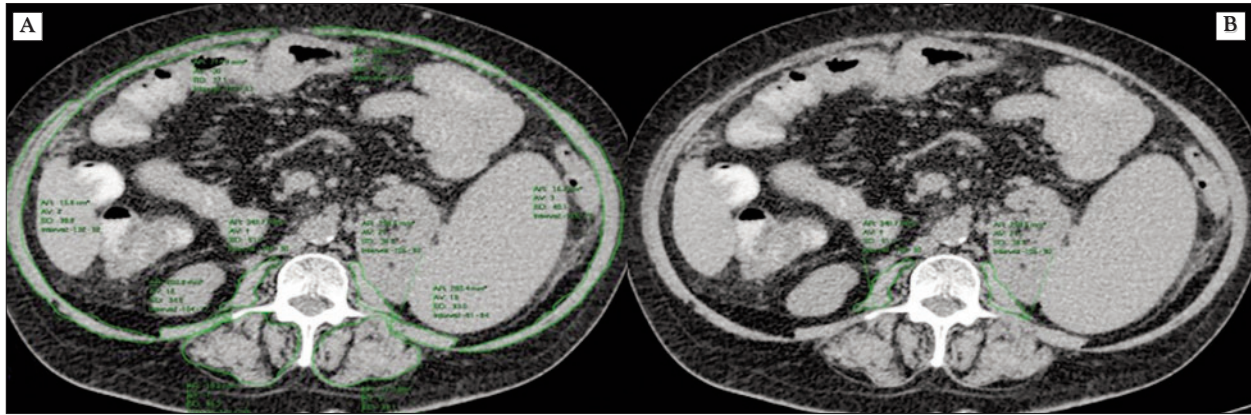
Native axial CT images demonstrating SMI values of 30 cm²/m² (A) and PMI values of 2.35 cm²/m² (B).
